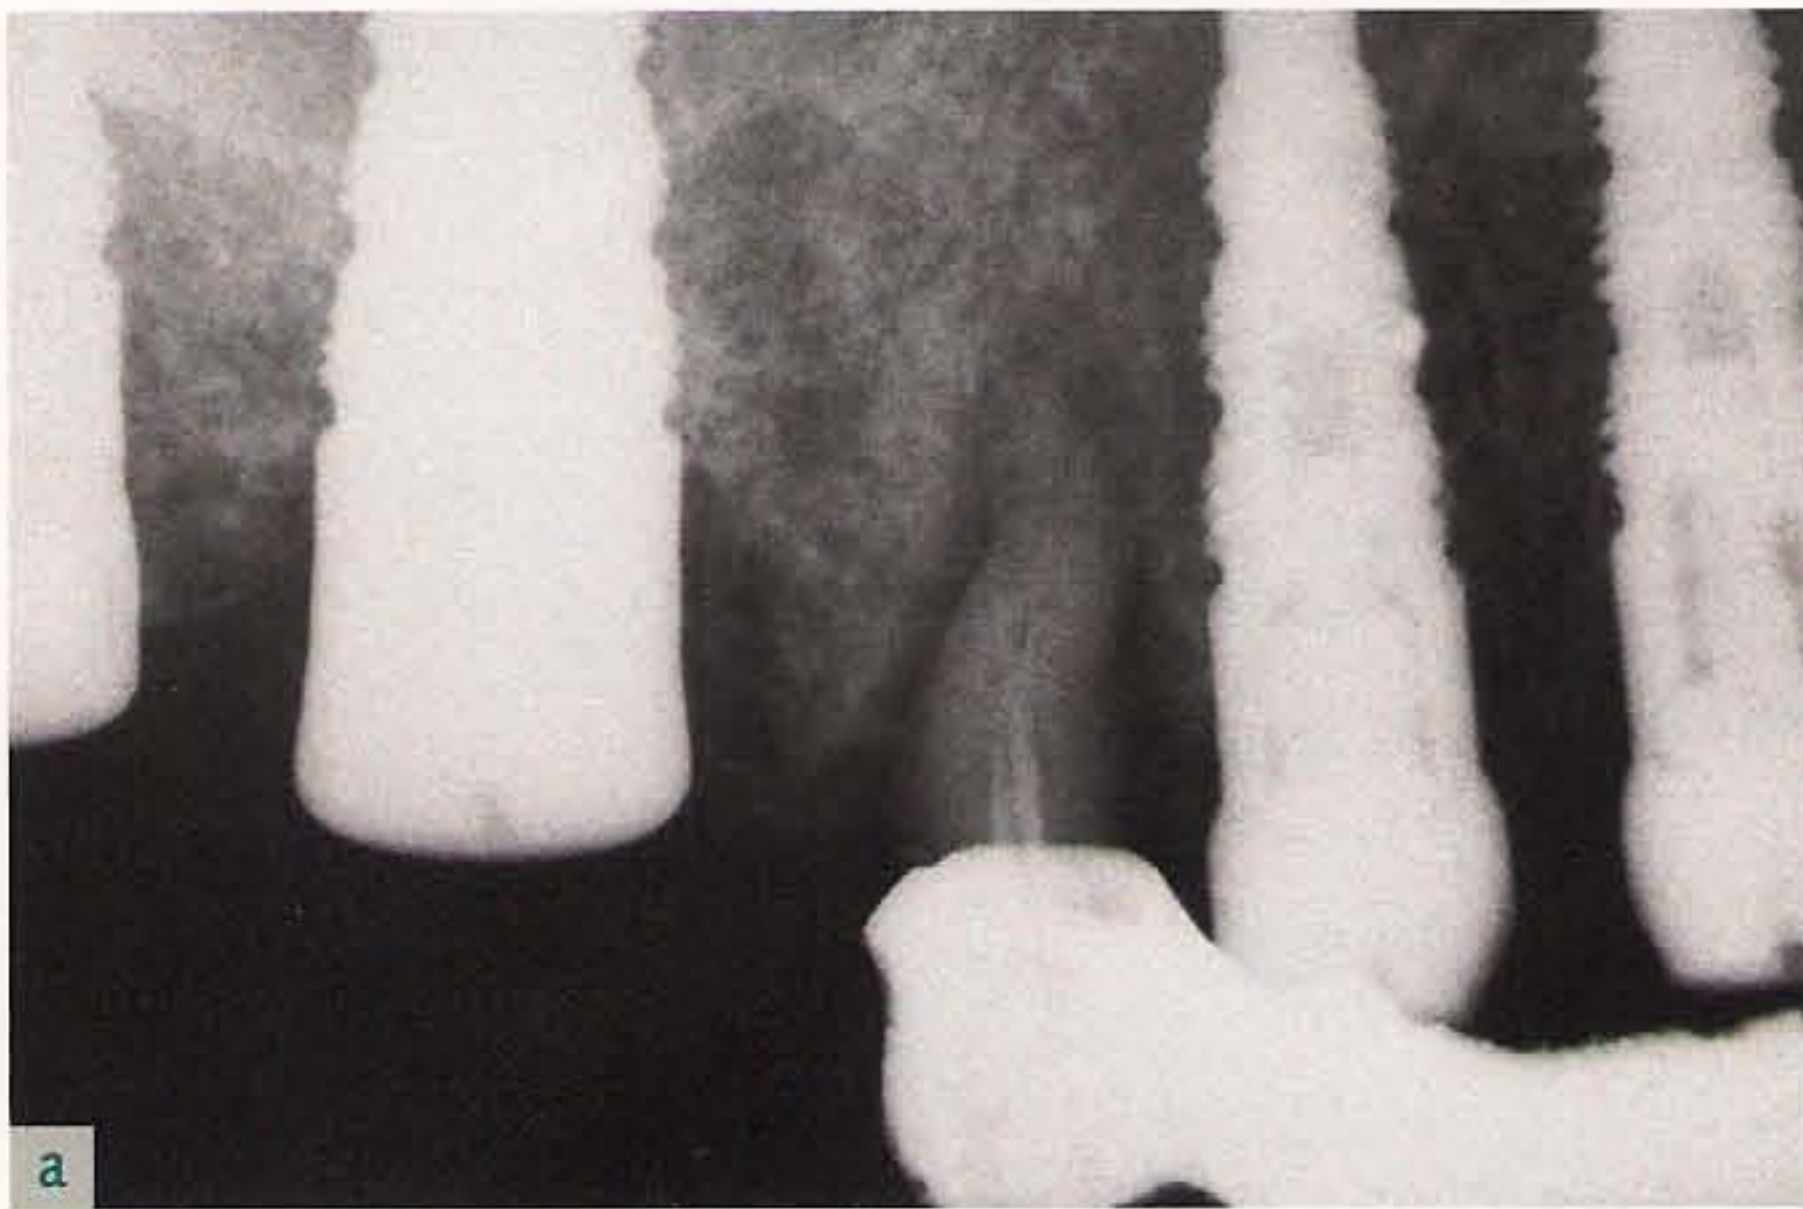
(a to d) Radiographs taken at stage 2 surgery reveal optimal healing.
